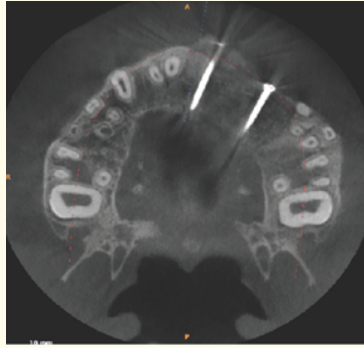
CT shows the end result of the bone craft.
